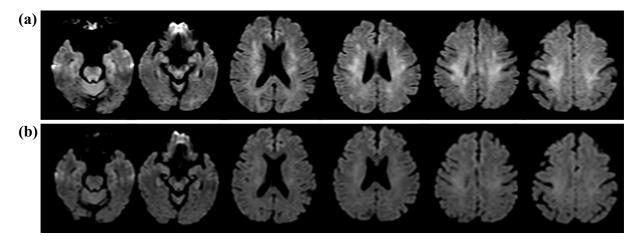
Brain diffusion-weighted magnetic resonance imaging (a) on admission and (b) four days later. High-signal areas were observed in the bilateral cerebral white matter and disappeared four days later without specific treatment.
